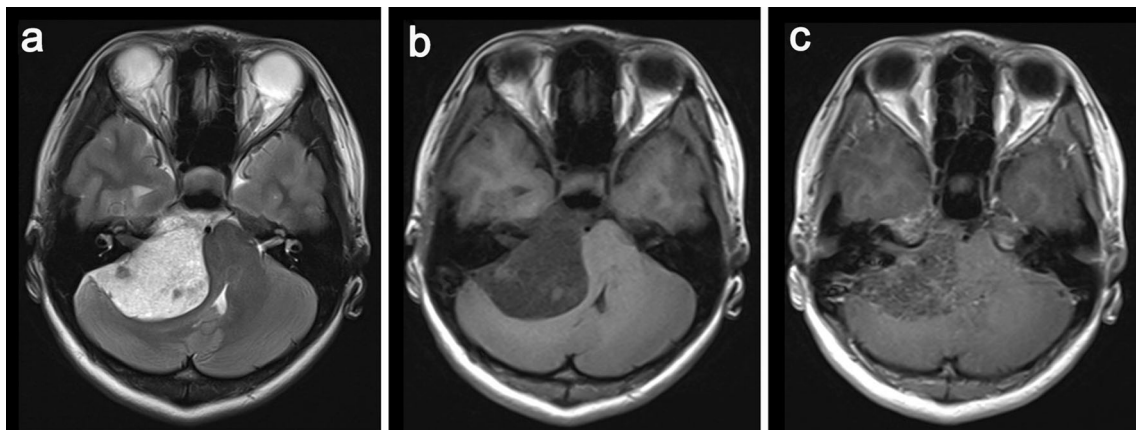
Patient 5. CCM at right CPA mimicking cholesteatoma. a T2-weighted image. b T1-weighted image. c Enhanced T1-weighted image
